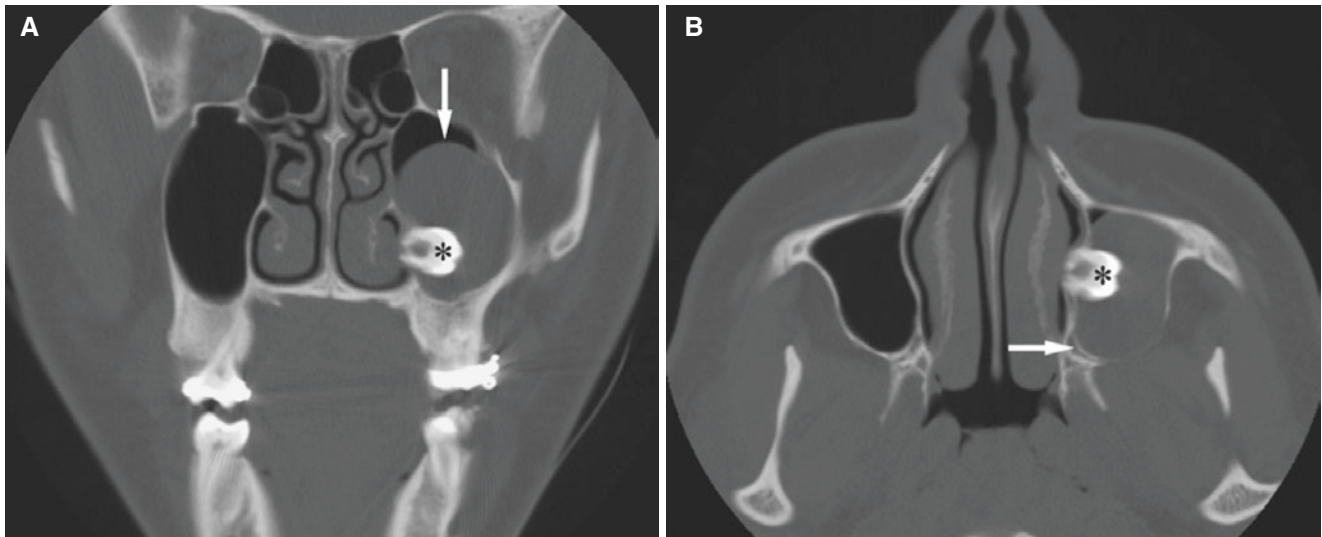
Maxillary follicular (dentigerous) cyst; 16-year-old female with impacted tooth. (A) Coronal CT image shows impacted tooth (*asterisk*) with corticated follicular cyst around the tooth crown (*arrow*). (B) Axial CT image shows evident corticated outline (*arrow*)
